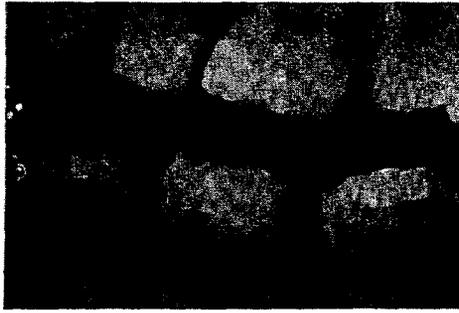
Radiograph of 25 DO, 35 DO Cerec restorations cemented with Cerec Duo luting agent and 36 MO Cerec restoration cemented with Cavex Clearfil F2 luting agent and with a class-V amalgam filling.
